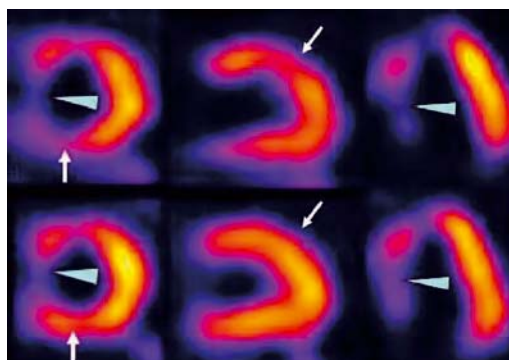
Example of a patient with a reversible defect as well as an irreversible defect on perfusion SPECT. Example of a patient with reversible perfusion defect in the inferior (white arrows short axis images) and anterior wall (white arrows vertical long axis images), and an irreversible perfusion defect in the septum (arrow heads short axis and horizontal long axis images). The upper panel shows from left to right the short axis, the vertical long axis and the horizontal long axis reconstructions after stress, the lower panel shows the same reconstructions during rest.
